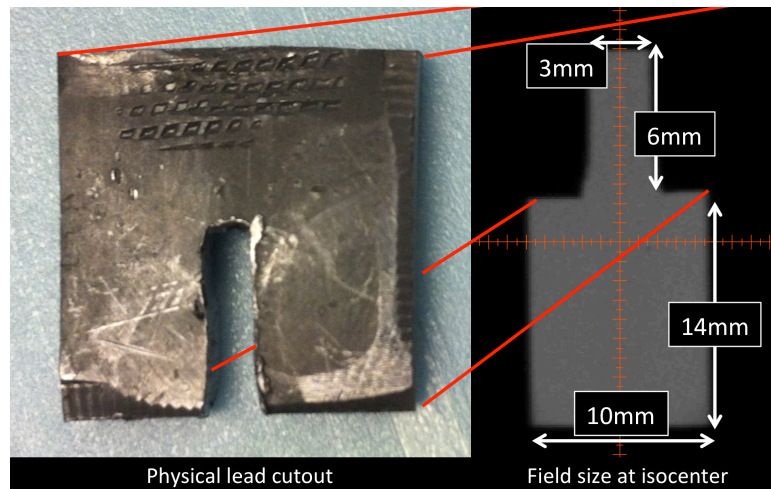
Lead block (~3mm thick) cutout (left) used to divide radiation field into large and small regions, along cone-beam projection image of actual radiation field at isocenter (right).
